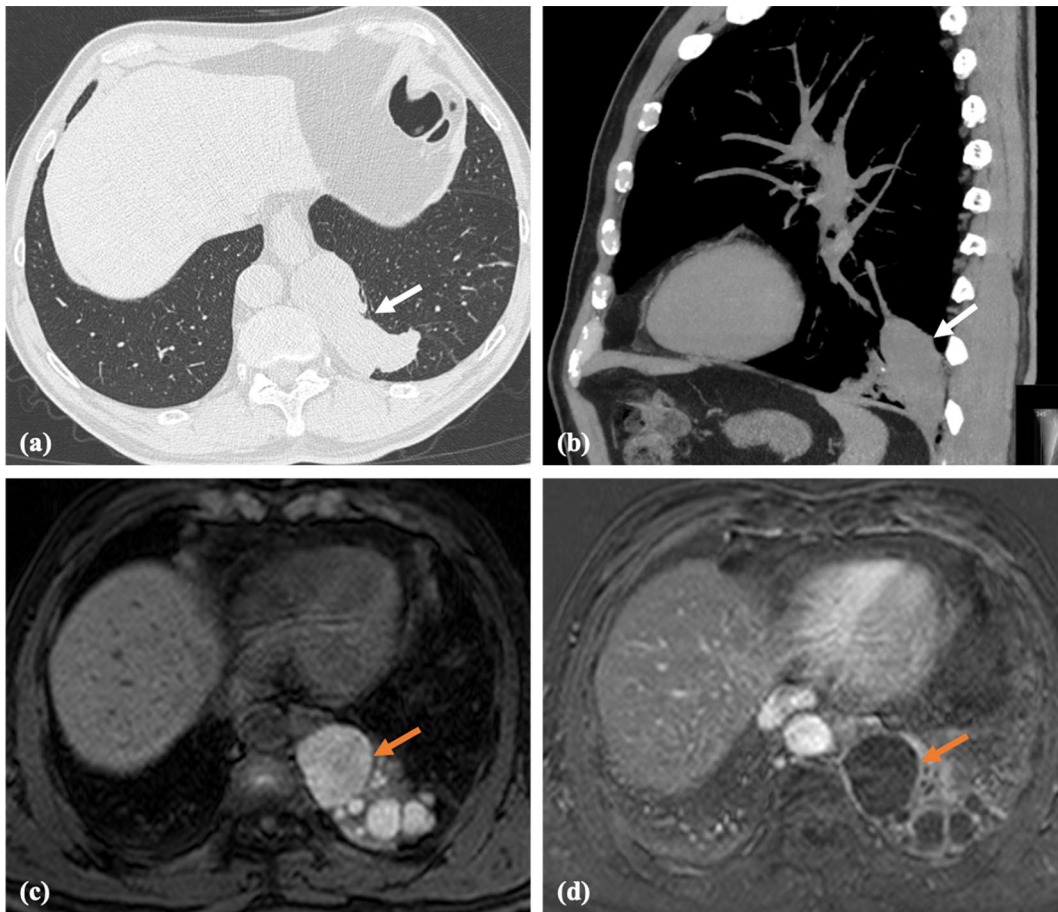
78 year-old-male with ABPA and previous history of tuberculosis. Axial (a) and sagittal (b) chest CT depict an elongated opacity in the left lower lobe consistent with saccular bronchiectasis packed with dense mucus plugs (white arrows).
